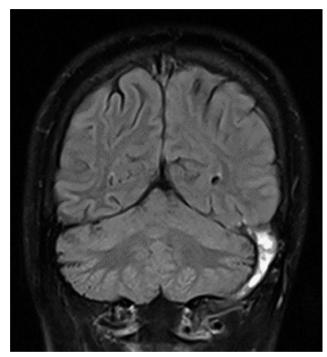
Coronal flair magnetic resonance image demonstrates high-intensity in the left transverse sinus compatible with thrombosis.
